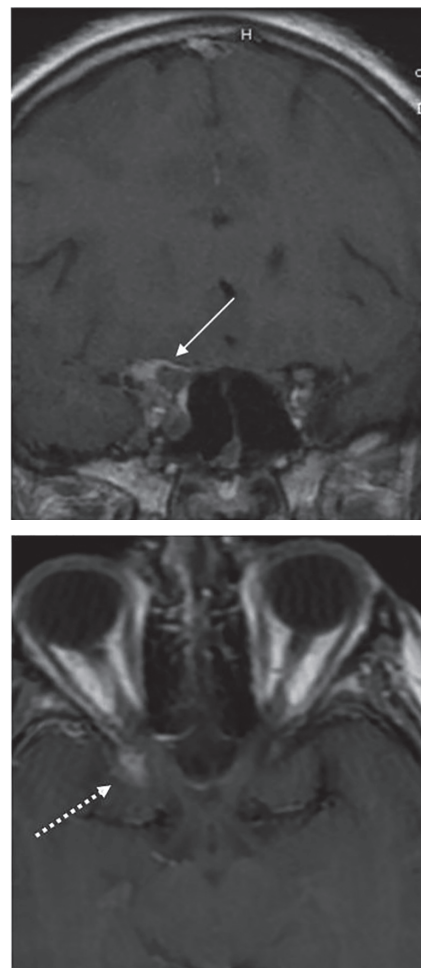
2. TSE T1 coronal (1) and axial (2) MRI images after gadolinium document the presence of pathological tissue characterised by enhancement in correspondence of the right cavernous sinus, suggestive for granuloma. The images also show an abnormal impregnation of the dura mater covering the right cavernous sinus and the anterior cranial fossa (Fig. 1, the white arrow), as well as of the anterior clinoid (Fig. 2, the dotted white arrow).
